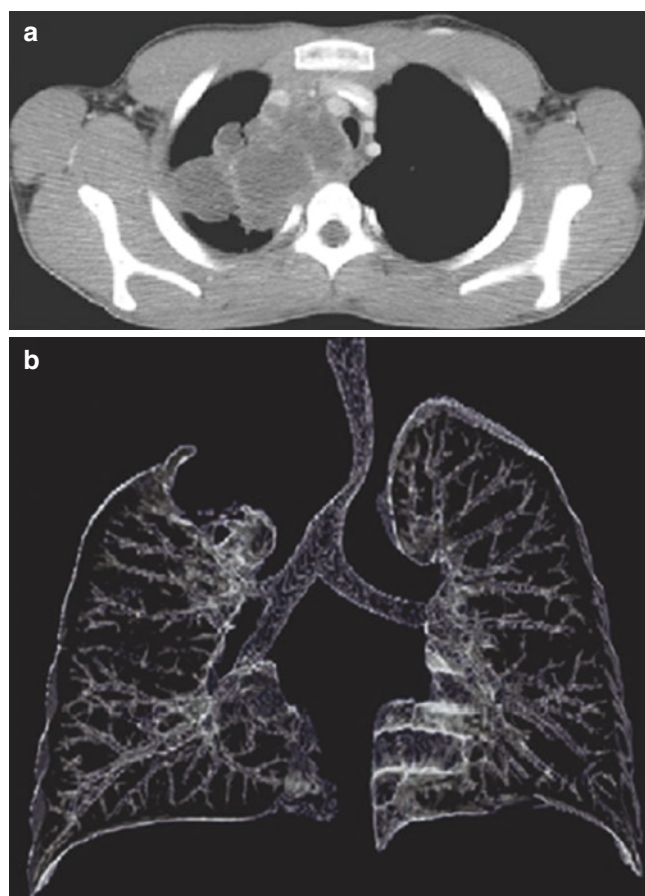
(a) Contrast-enhanced CT shows heterogeneous metastatic lymphadenopathy resulting in tracheal compression in a child with metastatic prostate rhabdomyosarcoma. (b) 3D-volume-rendered image shows a compressed trachea, which shifts to the contralateral side of the mass. Also noted is a metastatic mass compressing the right upper lung. (From Lee and Siegel [29], with permission)
